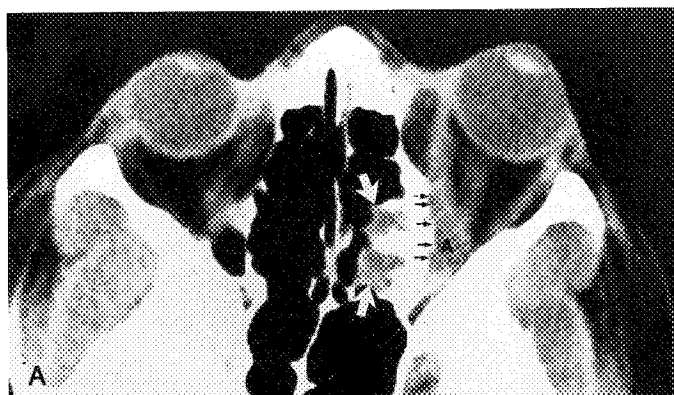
A, CT scan shows an ill-defined mass (*white arrows*) involving posterior, ethmoid-air cells. Note sclerosis of the medial orbital wall (*black arrows*) and soft tissue infiltration into the orbital apex. Proton-weighted (B) and T2-weighted (C) MR image showing orbital component of chondrosarcoma (*arrows*).
